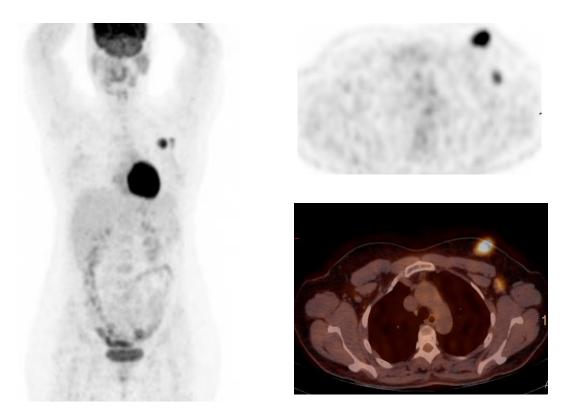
PET/CT for a 42-year-old female patient with hypermetabolic left uni-focal upper outer quadrant breast lesion pathologically proven infiltrative duct carcinoma, grade II with hypermetabolic left axillary lymph nodes. Clinical Staging: T1N1M0 Stage 2, ER negative, PR positive. PET/CT metabolic parameters for primary neoplasm (SUV max8.9, SUVmean5.2, MTV6, TLG31.3, TLR5.7 and size 2.2 cm). PET/CT metabolic parameters for metastatic lymph nodes (SUVmax4.8, SUVmean2.7, MTV4.2, TLG 11.8, TLR 3.1 and size of the largest lesion 1.3 cm.
